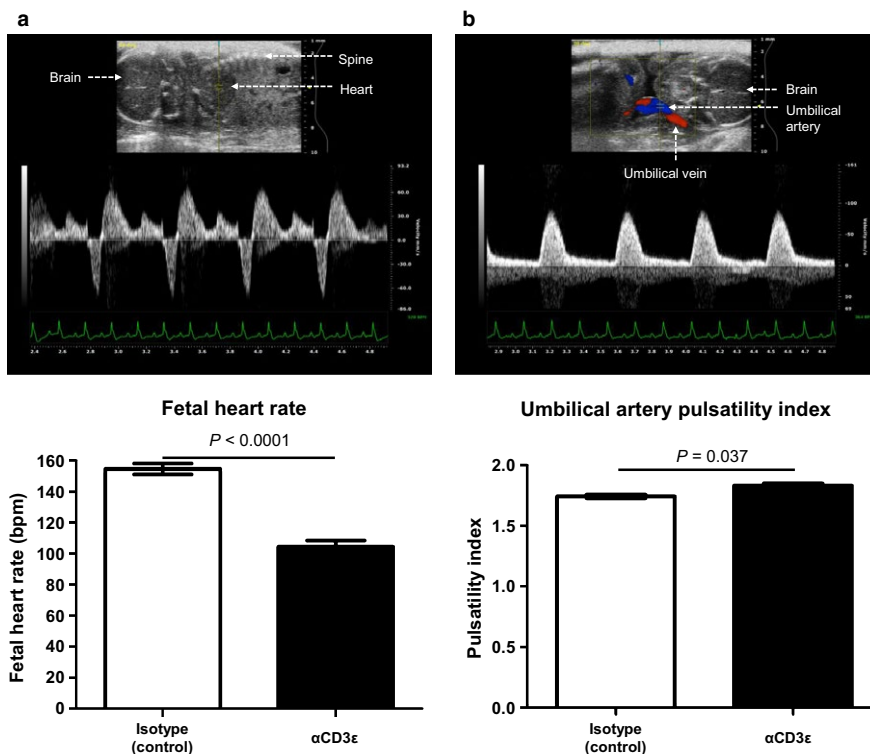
In vivo imaging by Doppler ultrasound. Doppler ultrasound was performed on fetuses prior to preterm labor/birth in dams injected with a monoclonal α CD3 ϵ antibody (10 μ g dissolved in 200 μ L of sterile 1X phosphate-buffered saline [PBS]; $n = 13$) or time-matched isotype controls (10 μ g dissolved in 200 μ L of sterile PBS; $n = 12$). Fetal heart rate (a) and umbilical artery pulsatility index (b) were recorded. Data are from 12 to 13 independent litters
